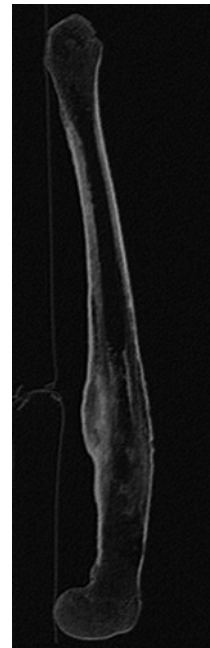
CT scan sagittal plane multiplanar reconstruction: the posterior aspect of the cortical bone is enlarged with sub-cortical hyperdensity area
